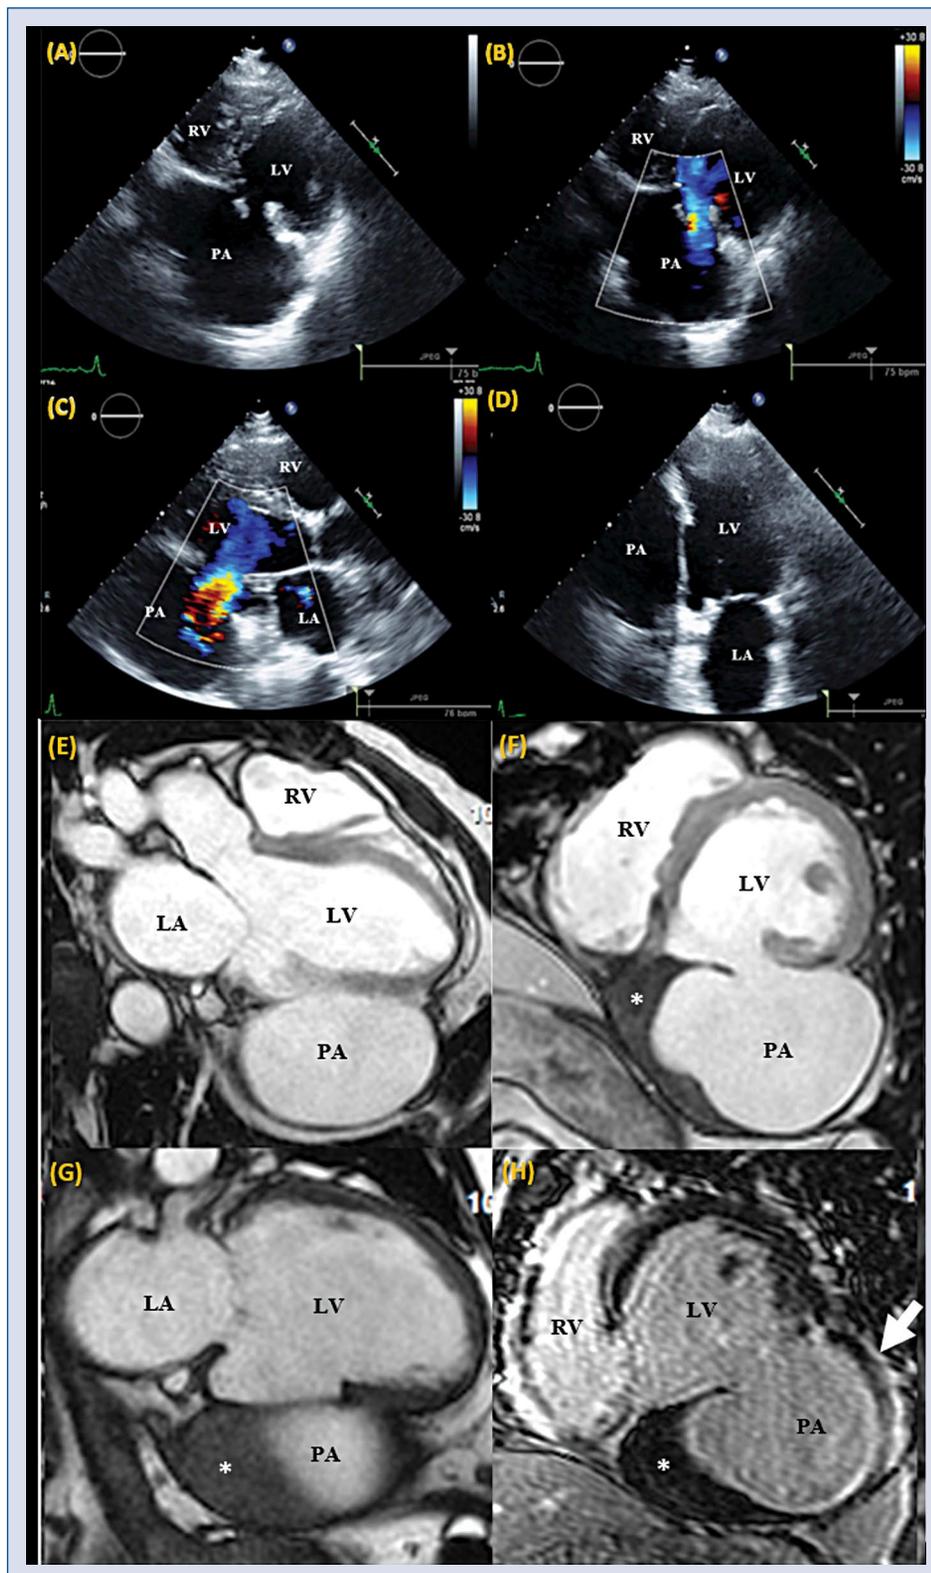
Transthoracic echocardiography parasternal short-axis views (A, B) and long-axis view (C) showing a pseudoaneurysm cavity that communicates with the inferior and inferolateral walls of the left ventricle (LV) through a narrow neck. Transthoracic echocardiography apical two-chamber view showing its relationship with the inferior wall (D). Cardiac magnetic resonance imaging — STIR image, oblique left ventricular outflow tract view (E), short-axis view (F) and two-chamber view (G) showing inferior free wall rupture with a large bulging aneurysmal sac containing a thrombus (*) that is adherent to the pericardial space. Delayed gadolinium enhancement of the pericardium adjacent to pseudoaneurysm (arrow) (H); LA — left atria; PA — pseudoaneurysm; RV — right ventricle.
